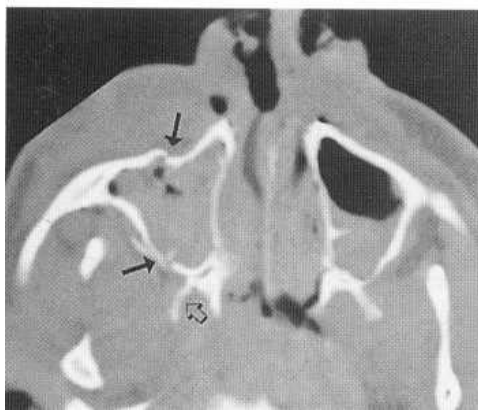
CT of facial fracture. (A) Fractures are identified through the anterior and lateral walls of the right maxillary sinus (arrows), and pterygoid plate (open arrow). There is complete opacification of the right antrum and nasal passage from haematoma, and a fluid level in the left antrum due to a maxillary fracture (not seen on this image). On another cut (B) the zygomatic arch fracture is also seen (arrow), and there is obvious depression of the zygoma. The left maxillary fracture is also seen (open arrow).
